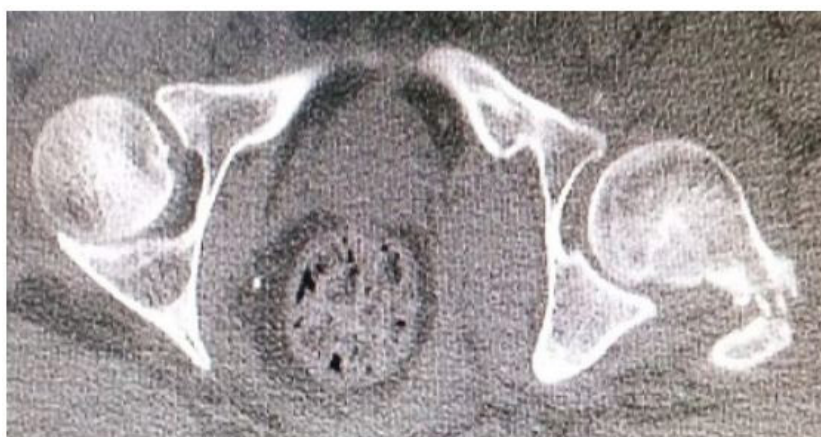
Post-reduction Pelvic CT scan
